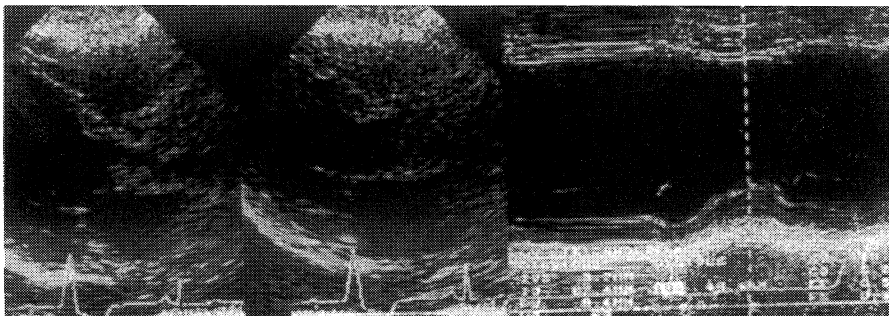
Echocardiogram. A | B | C
